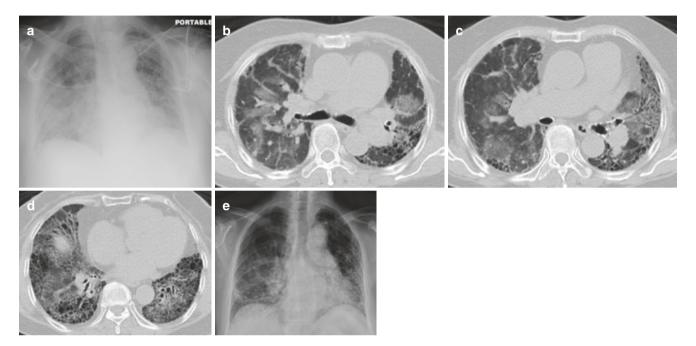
UIP with pulmonary edema. (a) Chest radiograph at presentation shows diffuse GGOs and an enlarged heart with clinical features of heart failure. (b-d) HRCT images from next day show dilated central
